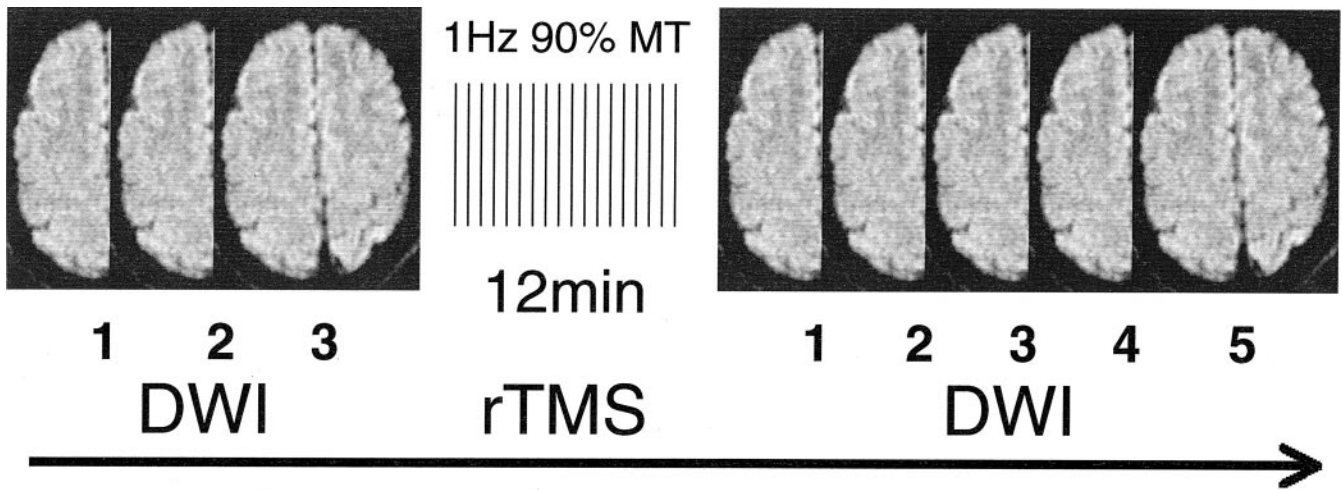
Experimental design: three diffusion-weighted imaging (DWI) MR data sets were acquired before the 12-minute, 1-Hz rTMS train, and five DWI MR data sets were acquired after the train. The 1st diffusion scan was acquired 70 to 90 seconds, the 2nd was acquired 180 to 240 seconds, the 3rd was acquired 300 to 360 seconds, the 4th was acquired around 420 seconds, and the 5th was acquired around 570 seconds after the rTMS train.
